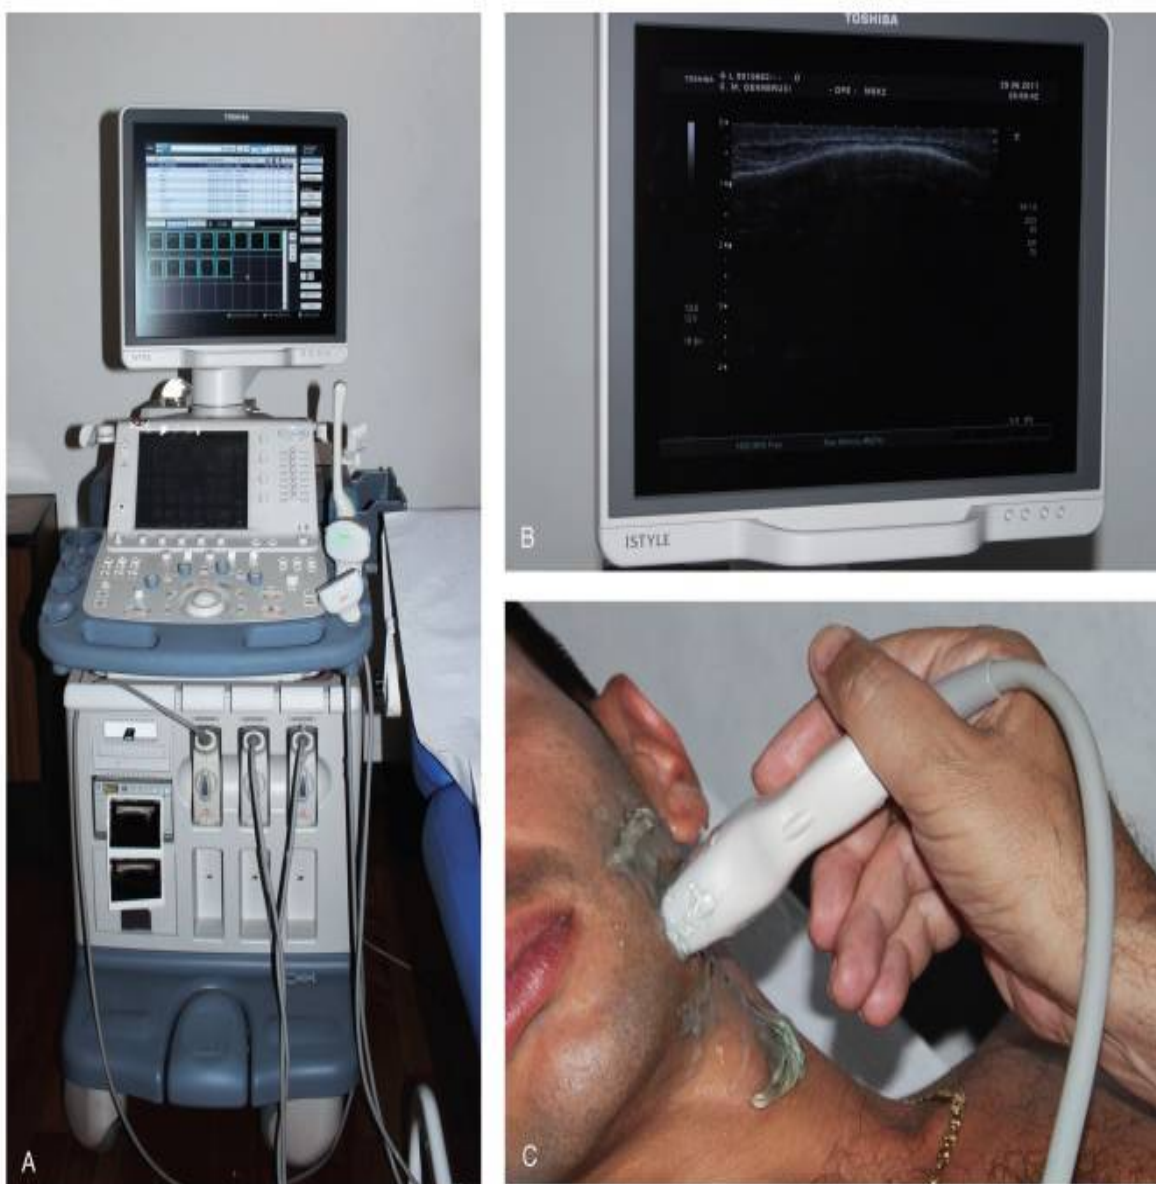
Ultrasound in Endodontics
